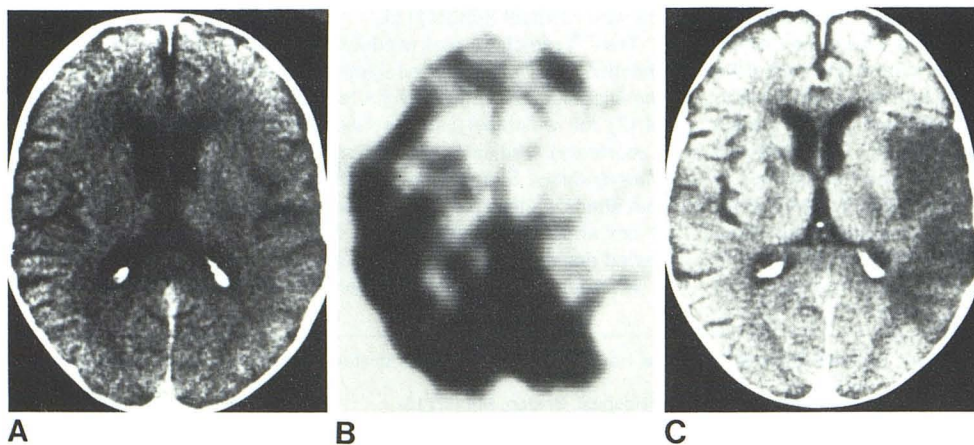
Stroke patient. A, Initial CT scan on day of acute onset of right hemiparesis shows no abnormality. B, SPECT-IMP scan at same level. Large area of decreased activity in left hemisphere in region of distribution of middle cerebral artery corresponds to clinical findings. C, CT scan 1 week later. Area of edema in left hemisphere in region of previously noted perfusion deficit on SPECT-IMP.
